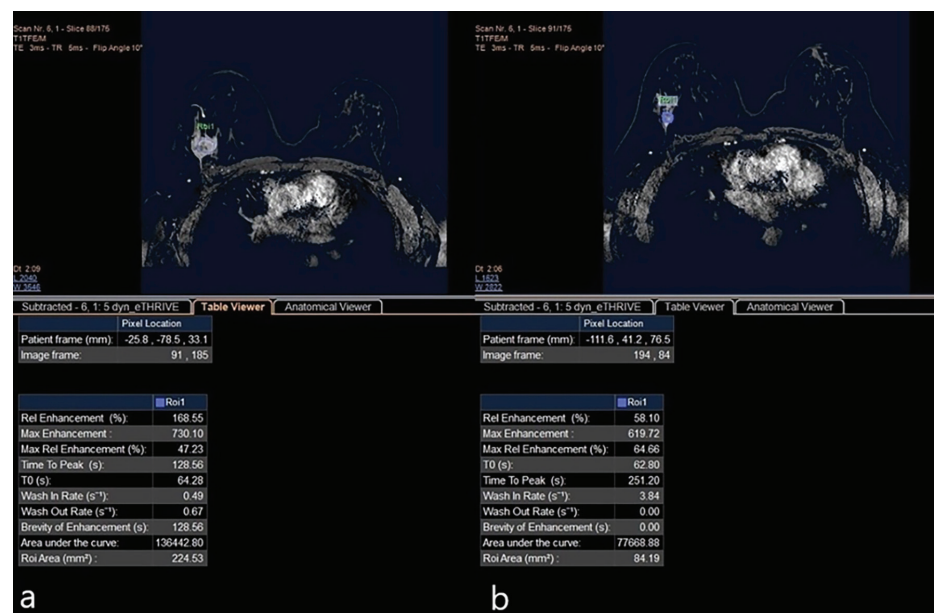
Changes in dynamic contrast-enhanced magnetic resonance imaging baseline (a) and post-neoadjuvant therapy (b) parameters of the same patient. Although there was a significant change in all dynamic parameters in this patient, the pathology result was a partial response.
